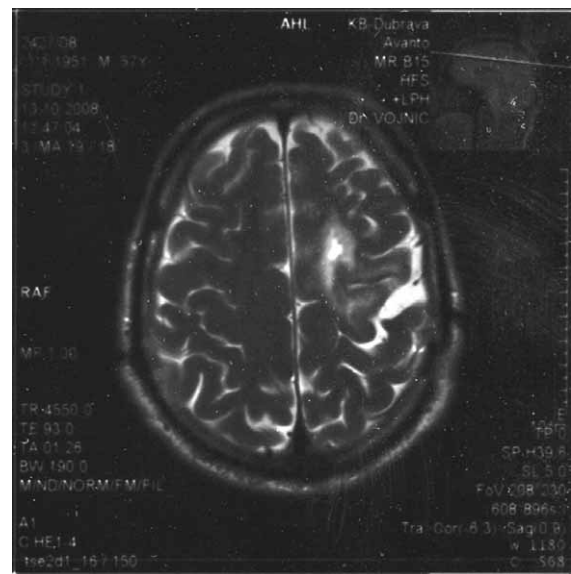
MRI in 2008 (5 years after the surgery) showed gliosis without the residual tumor.
